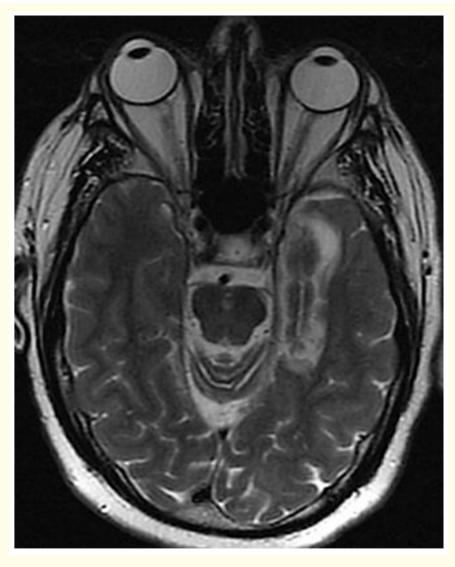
Post-surgical MRI showed ablation of left hippocampus and amygdala (T2W1).
